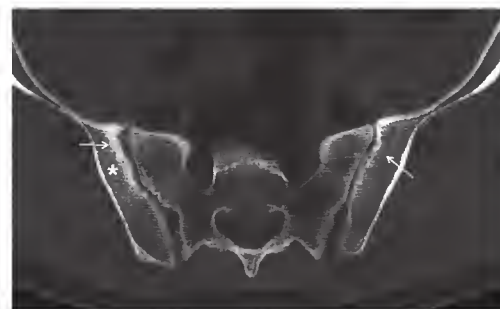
Computed tomographic scan of the sacroiliac joints of a patient with ankylosing spondylitis. Note the areas with erosions (arrows) and sclerosis (asterisks), which represent characteristic signs of the disease.
